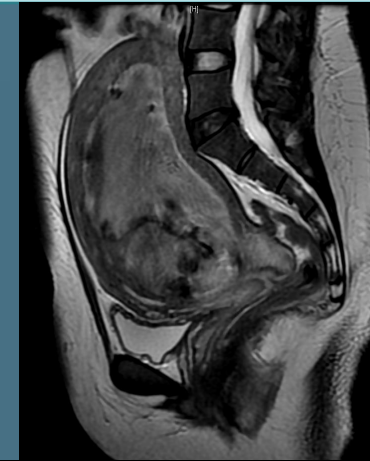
MRI Pelvis 2 months post-UAE. Fibroid now measures 14x8cm and majority has devascularised. Fibroid now communicates with endometrial cavity
